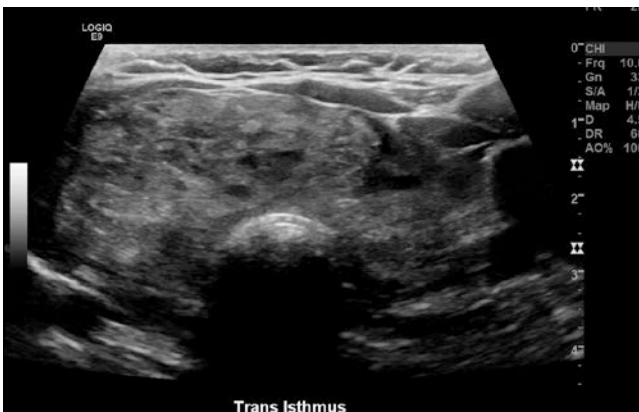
Ultrasound image of bilateral diffuse enlargement of the thyroid. A US can be inadequate for imaging when there is significant extension of the thyroid into the thoracic inlet
